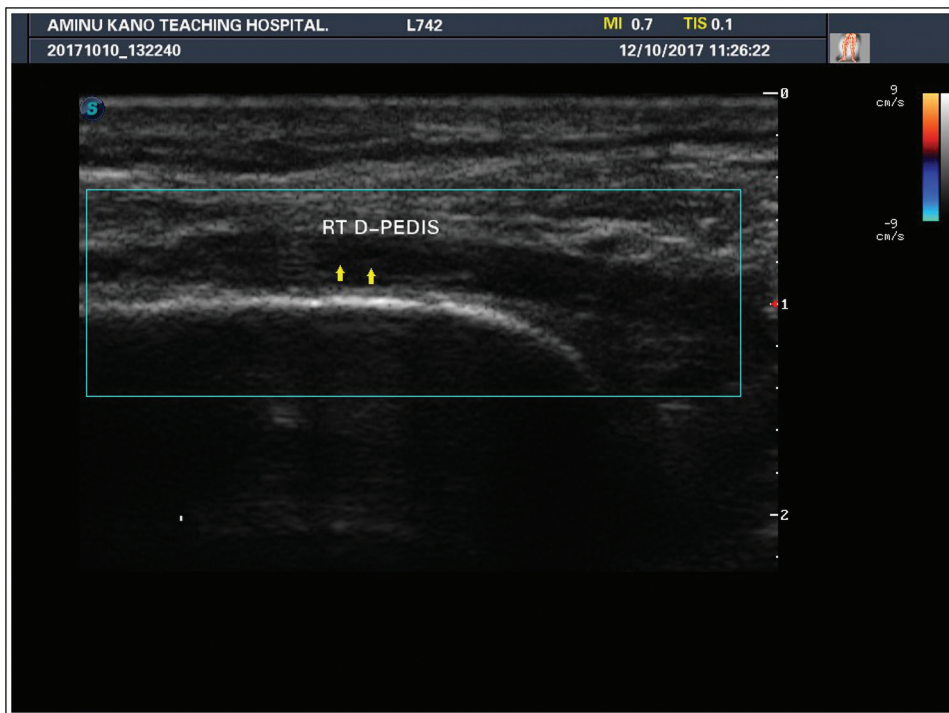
A colour Doppler sonogram of the right dorsalis pedis artery, showing extensive atheromatous plaque, occluding the lumen of the artery
